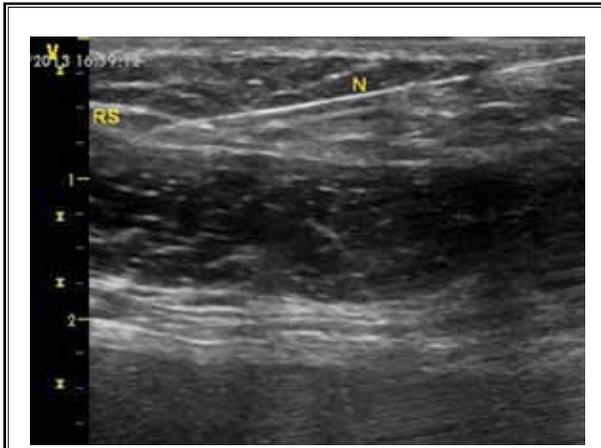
Ultrasonographic view of needle course and spread of injectate along the rectus sheath.
